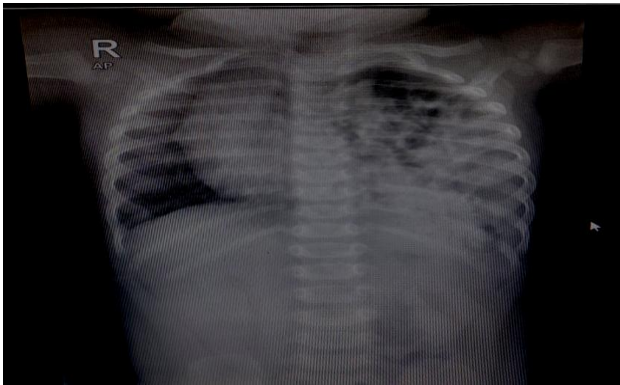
Chest X-ray shows intestinal loops in left thoracic cavity and no stomach bubble, suggesting left sided congenital diaphragmatic hernia.
